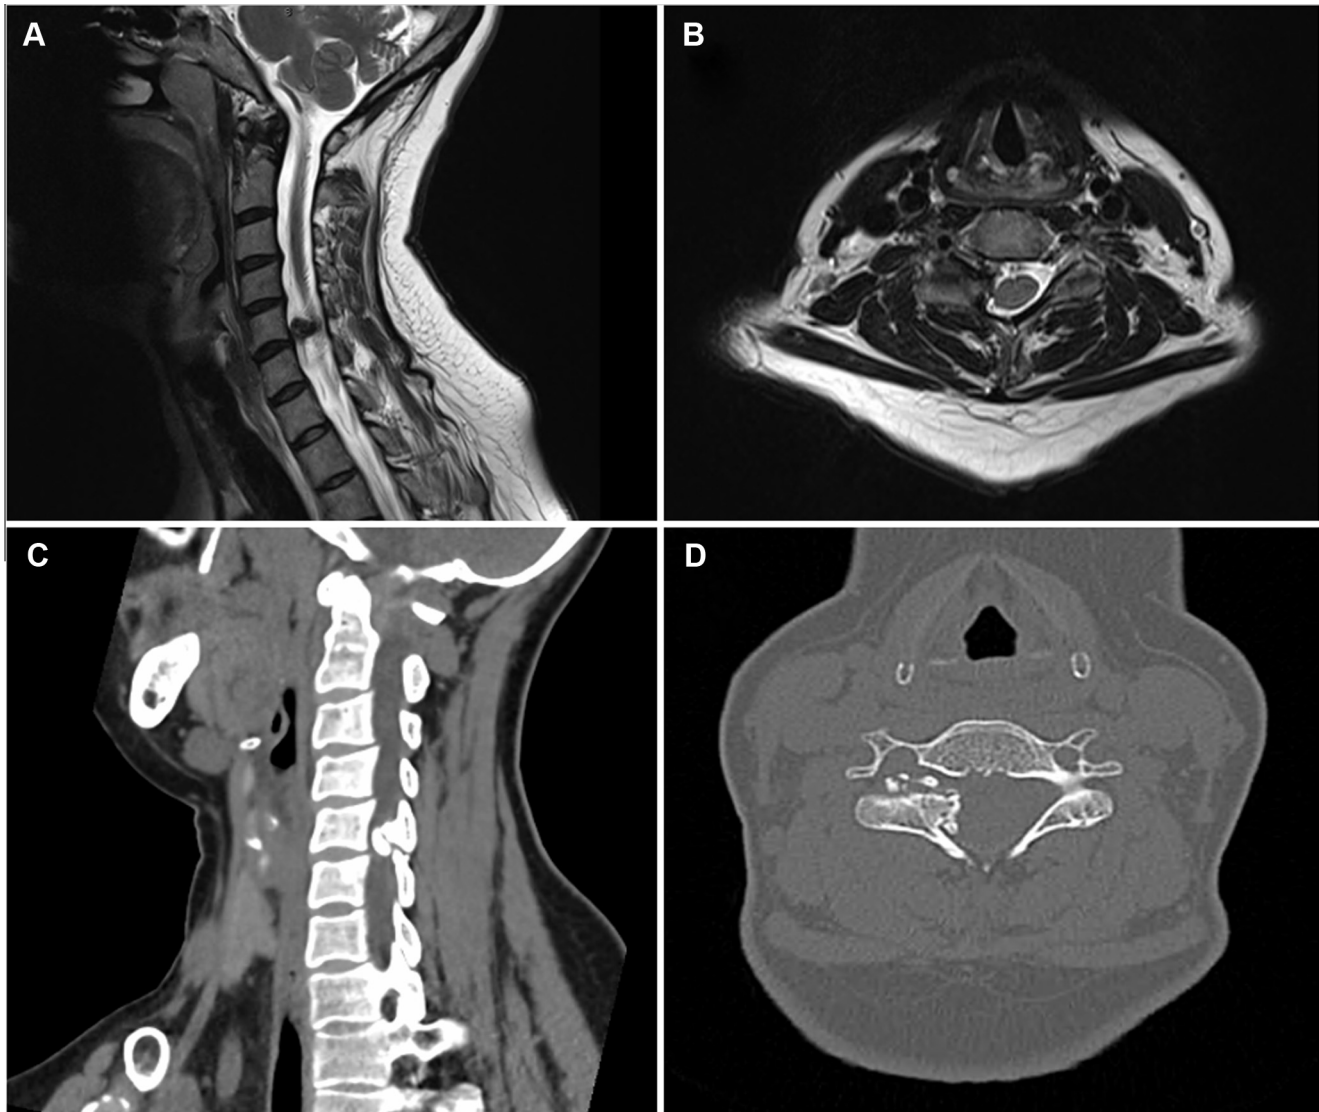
(A) Sagittal T2-weighted MRI, (B) axial T1-weighted MRI, (C) sagittal CT scan, and (D) axial CT scan showing vertebral canal stenosis at C5/C6 secondary to facet/synovial cyst.
